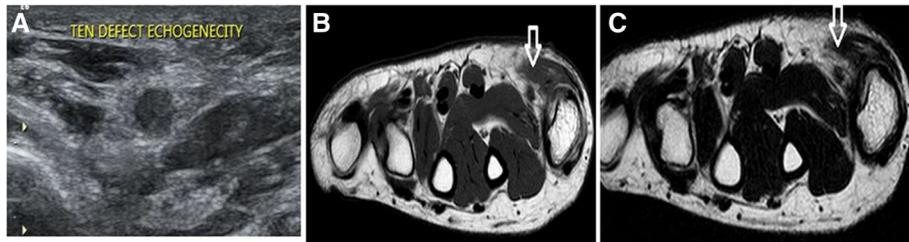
Complete tendon tear. a USG of the dorsal aspect of the wrist demonstrates complete FPL tendon tear. b, c Axial T1I and axial T2WI MRI of the wrist demonstrates abnormal SI of FPL tendon
